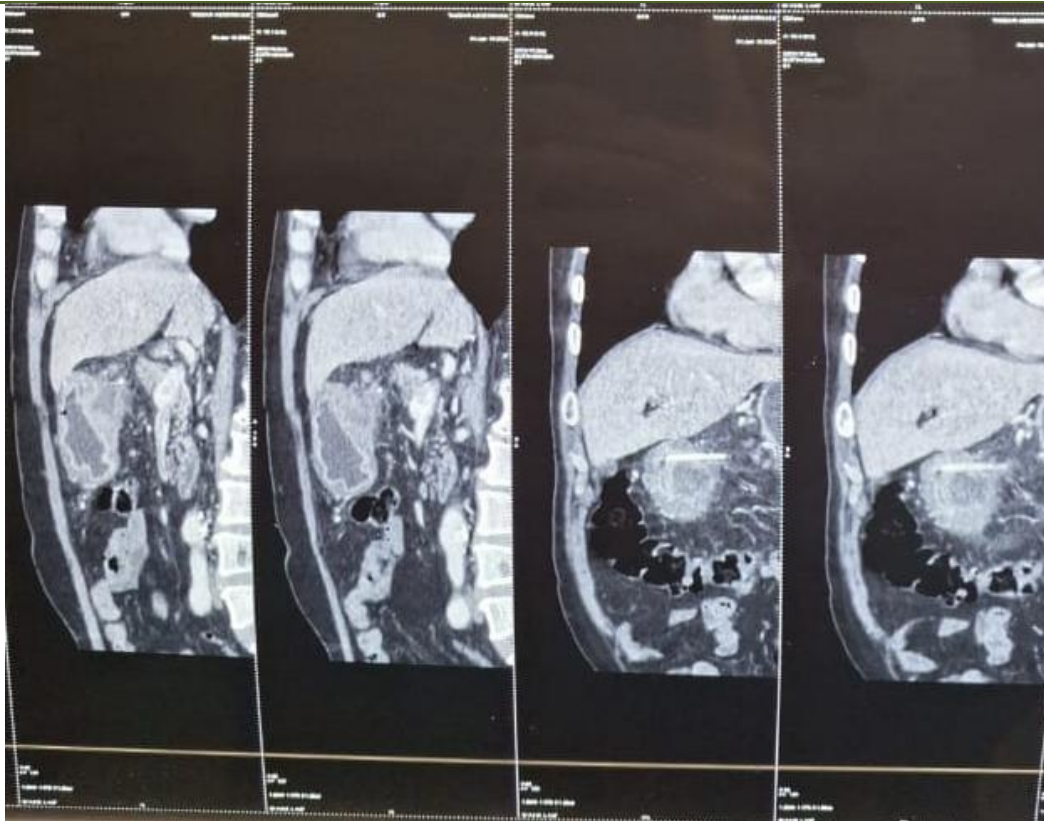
Cross-sectional imaging of abdominal CT reveals a linear foreign body 38 mm long, spontaneously hyperdense, transfixing the posterosuperior pyloric wall which is thickened and the site of an abscessed collection measuring 28 x 20 mm
